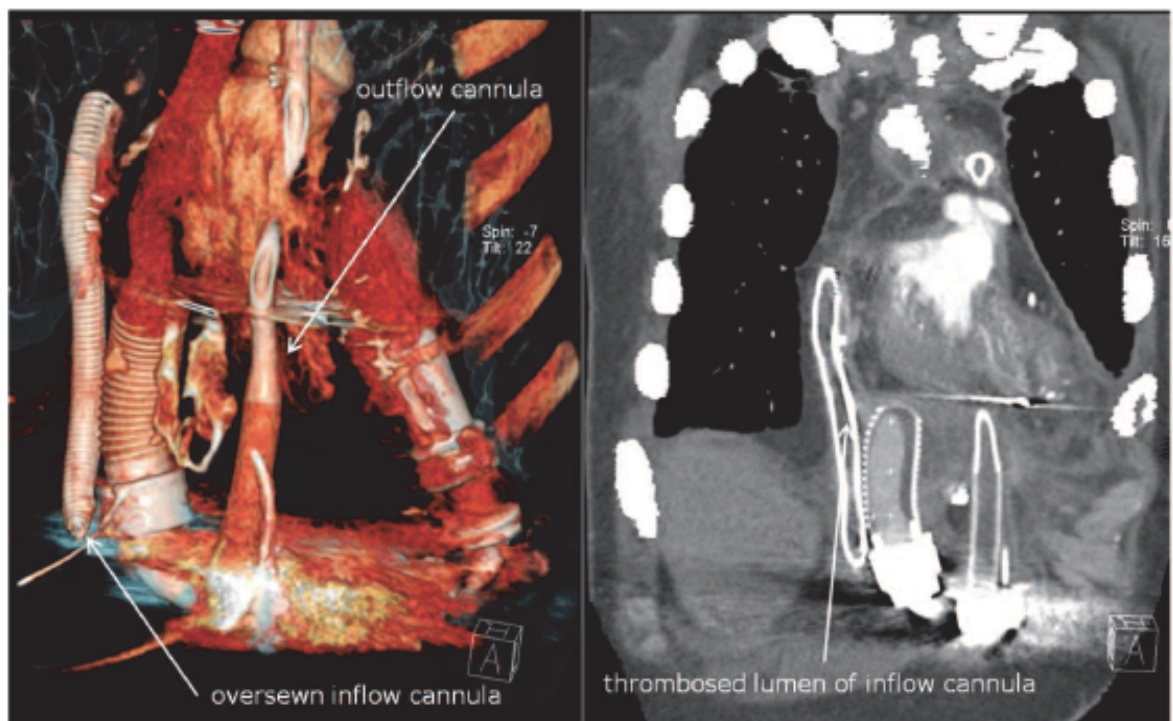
CT scan showing early cannula thrombosis and the location of the cannula tips. CT, computed tomography.
